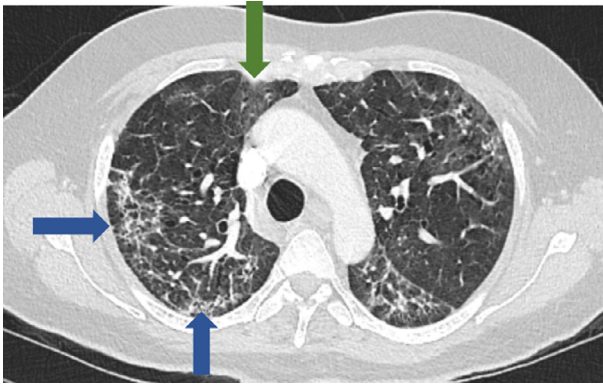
Computed tomography scan of the thorax on day 57 from admission, showing subpleural fibrotic appearance (blue arrows) and patchy ground glass changes (green arrow) without any focal consolidations.
